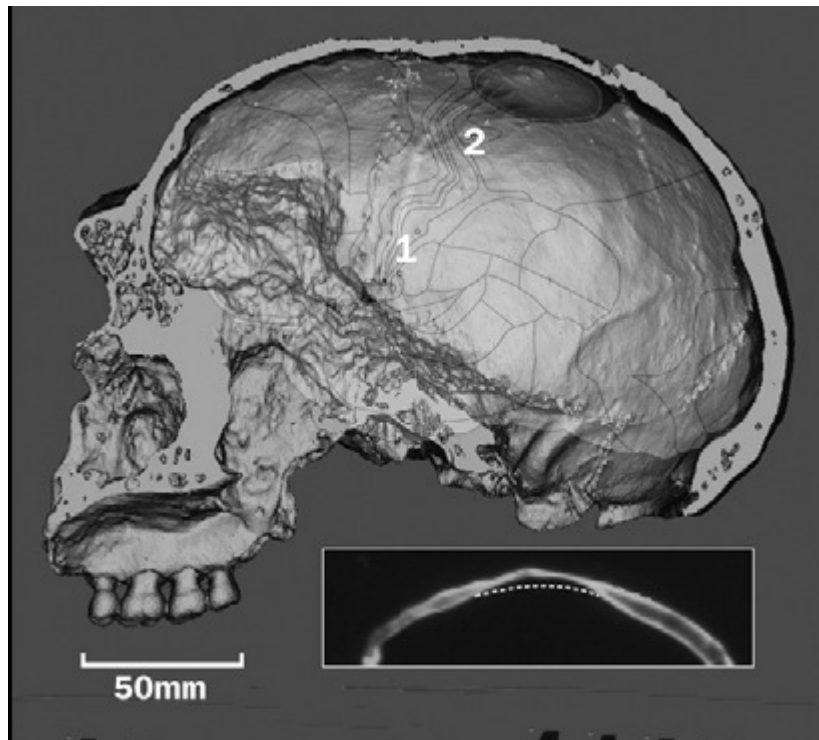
Lateral view of the median section of the reconstruction of the intravital situation. Sphenoparietal sinus (1), two widen branches of middle meningeal artery (2). At the bottom is a CT scan through meningioma region indicating the thinning of parietal bone. (Czarnetzki A. et al., 2003)
